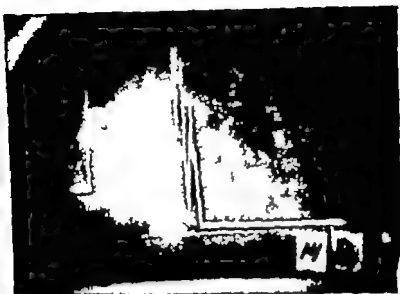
Examination *in vivo* through abdominal wall. Clear amniotic fluid was obtained by paracentesis immediately following the ultrasound examination. The broad echoes represent the solid tissues between the skin and the amniotic fluid. The fluid gave no echoes even with an amplitude of 0. The fetal component of the oscillatory pattern cannot be seen in this view—it was visible when the field was moved to the right to a point where the abdominal wall component disappeared. This was case of polyhydramnios.
